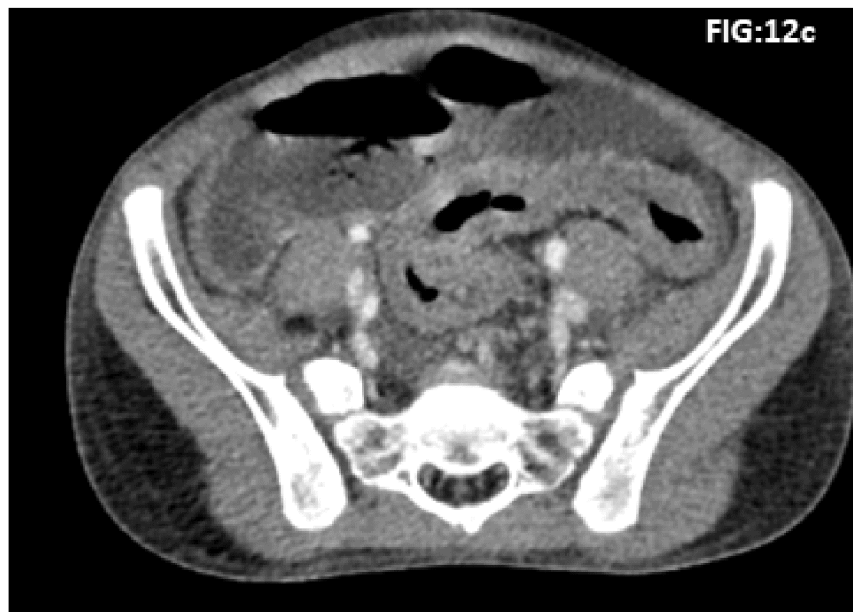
CT showing circumferential bowel wall thickening of descending and sigmoid colon
